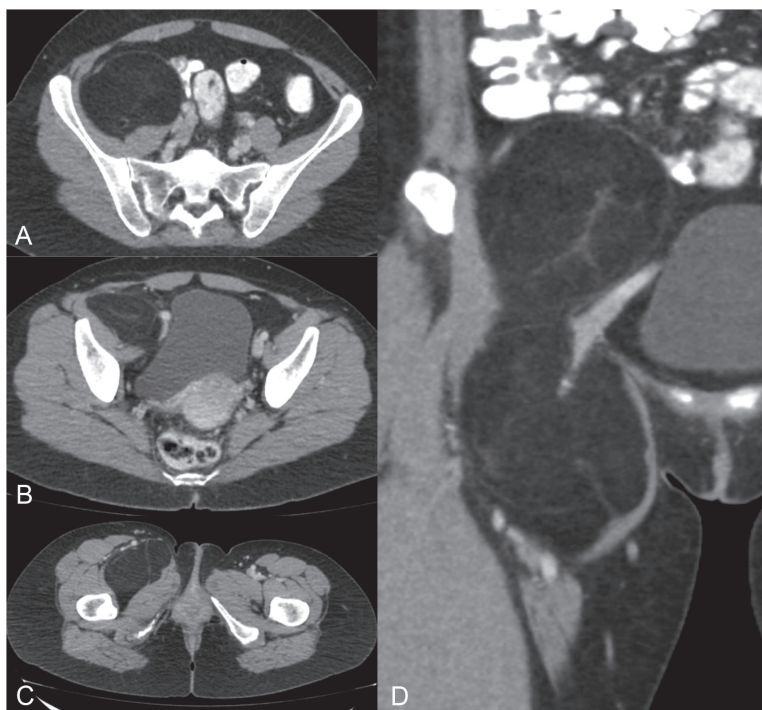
(a): CT scan axial-view showing a right retroperitoneal soft-tissue tumour in contact with the iliopsoas muscle and medially displacing ipsilateral iliac vessels. (b and c): Images showing herniation through inguinal canal into the thigh and displacing forwards the femoral vessels. (d): Coronal view of the tumour with a 'dumbbell appearance'. Biopsy: lipomatous tumour without MDM2 amplification on FISH.
